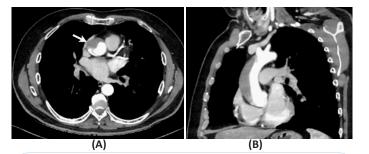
Post procedure CT angiography. (A) Axial enhanced view evidence a pooled extra luminal contrast in the aortic root with a false lumen 24mm thick. (B) Oblique enhanced view helps determine the extent of the dissection to the beginning of the aortic arch.
